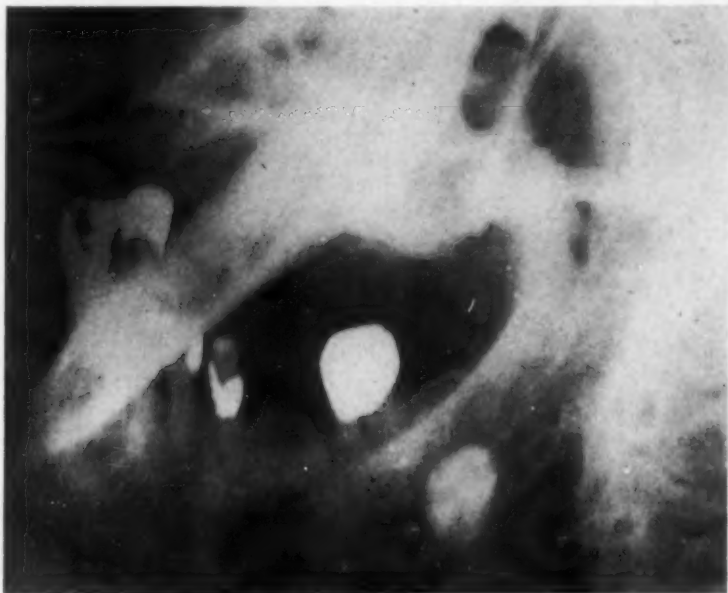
X-ray of submaxillary calculus superimposed on mandible.
